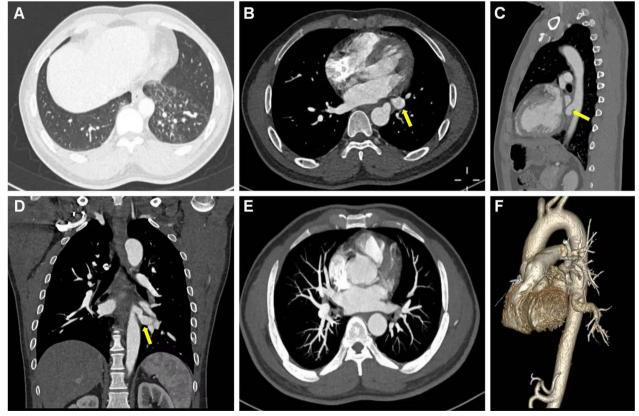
Preoperative contrast-enhanced pulmonary CT scan: A Lung window reveals multiple patchy opacities in the lower lobe of the left lung. B Mediastinal window reveals an anomalous artery originating from the thoracic aorta. C, D MPR reconstruction reveals the anomalous artery accompanied by the left lower pulmonary vein. E, F MIP (E) and VR (F) reconstructions demonstrate the anomalous artery originating from the thoracic aorta, with normal development of the left lower pulmonary artery
